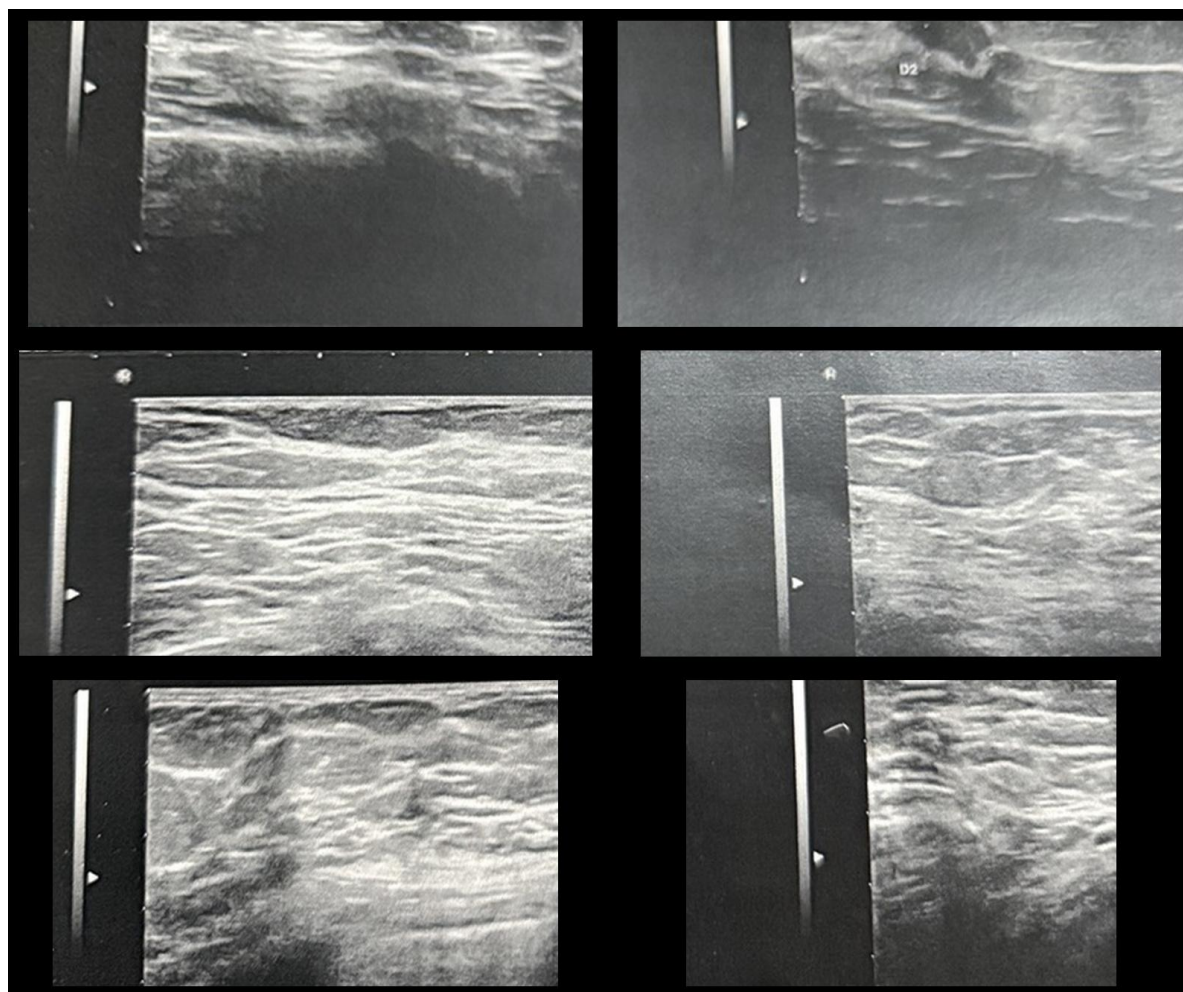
Targeted breast ultrasonography. Multiple views show the irregular hypoechoic, non-circumscribed lesion in the left breast, classified as ACR 5.
